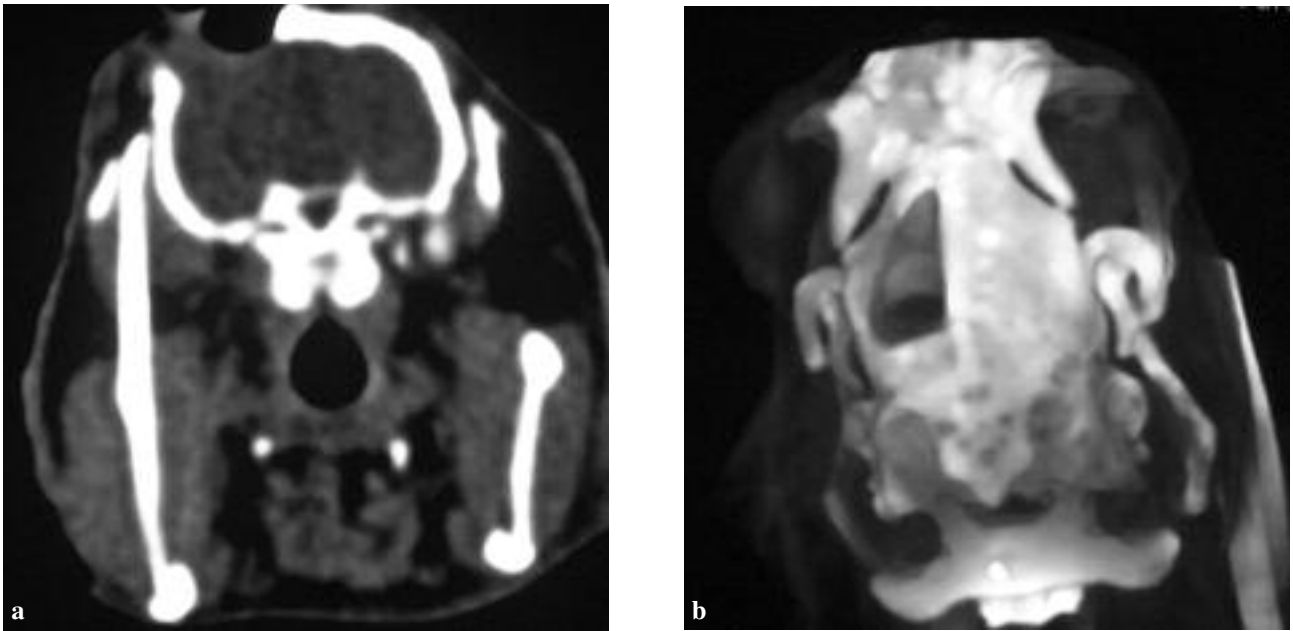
Three-dimensional CT image after head trauma was inflicted
